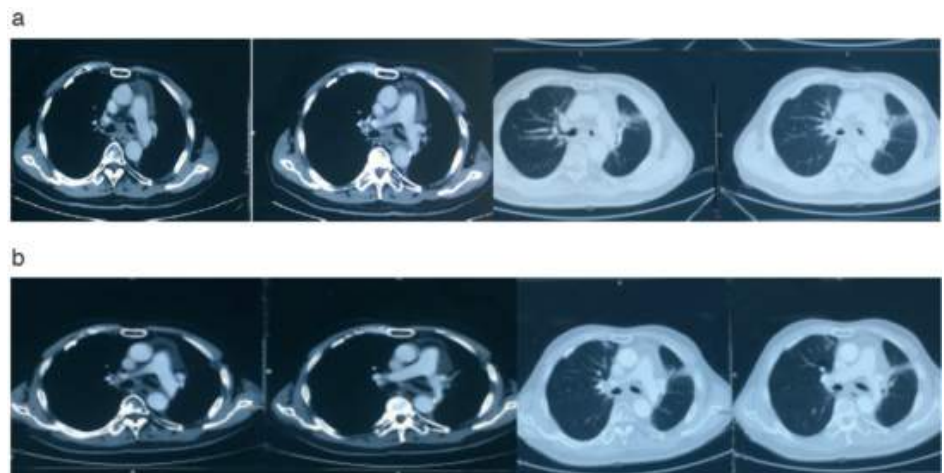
(a) CT scan showing PD before enrolled into Lux-Lung8.
